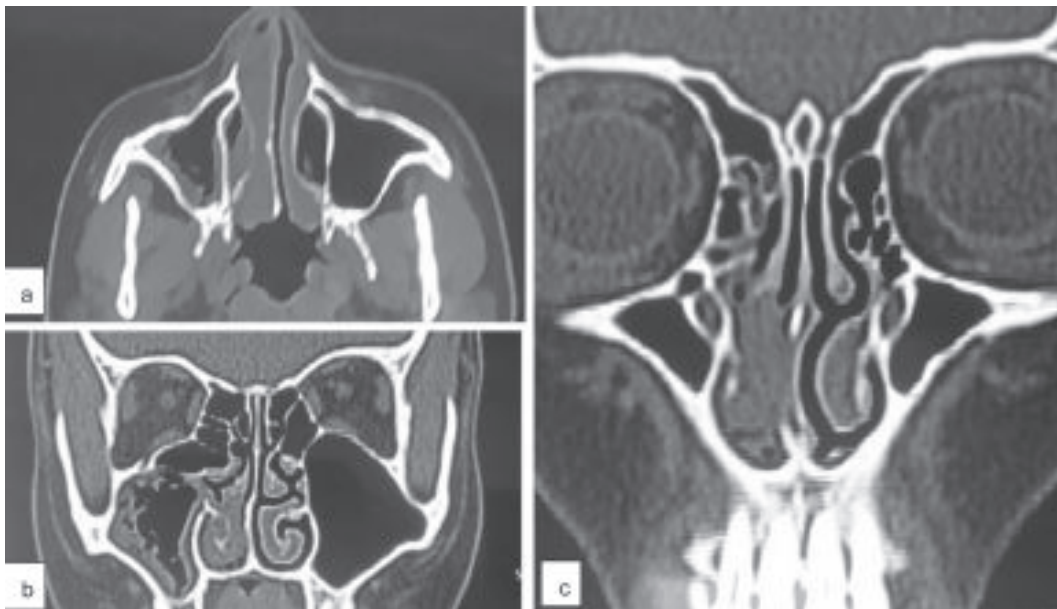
a-Computed tomography paranasal sinus in axial view showing mucosal thickening of the right inferior turbinate b and c-coronal views showing right inferior turbinate thickening and right maxillary sinus mucosal thickening
